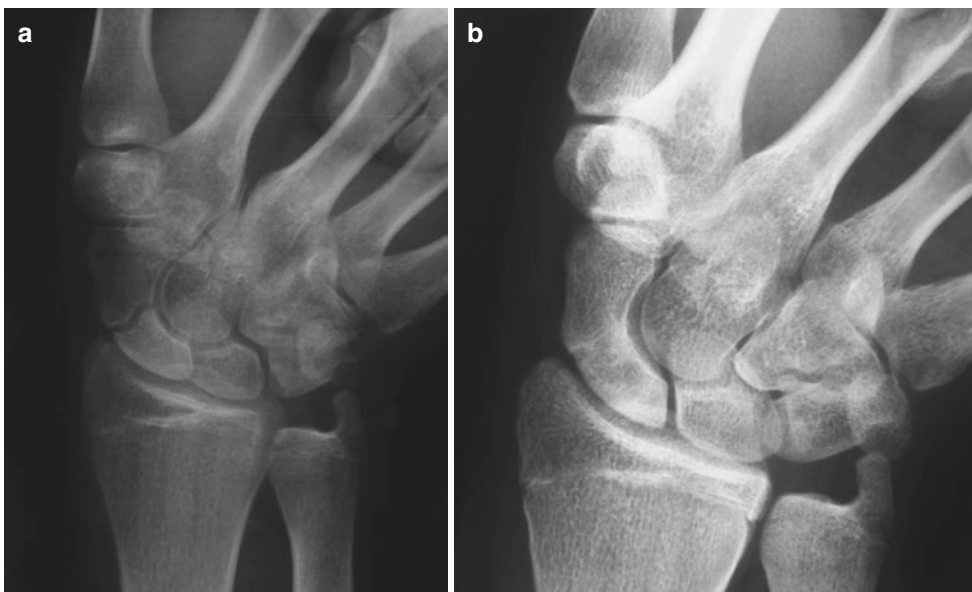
(a) Delayed union in a 16-year-old student. (b) X-ray after conservative treatment with splint and Osteobit[®] for 2 months
